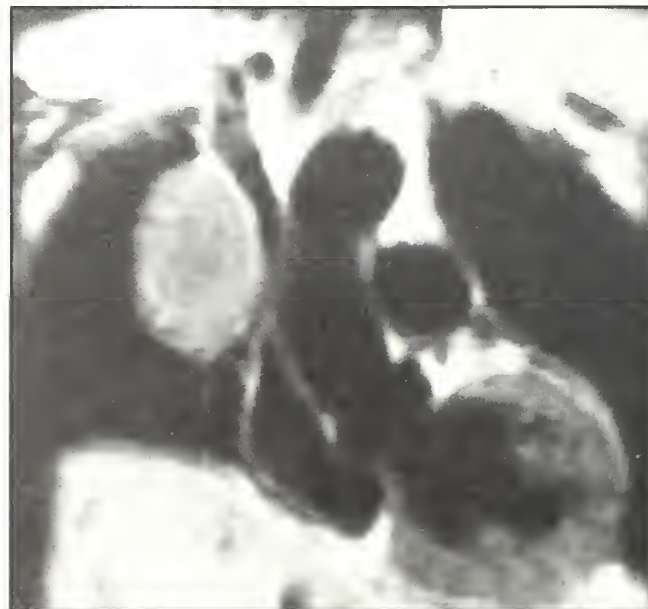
Coronal T₁-weighted MRI showing a large homogenous mass indenting the superior vena cava.
